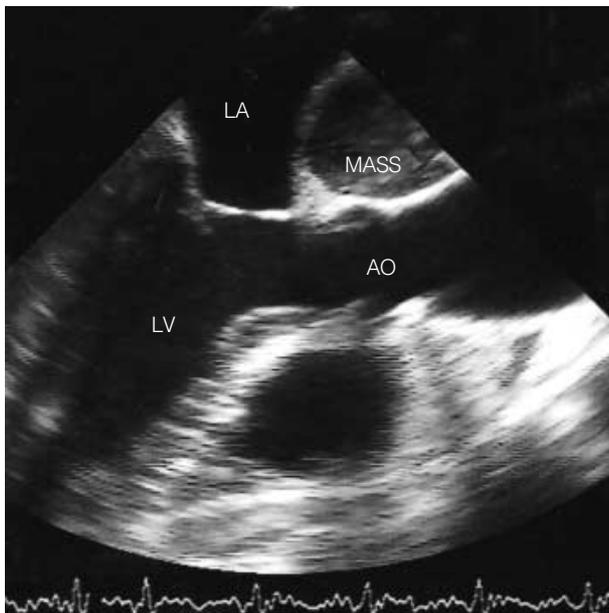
Transesophageal echocardiogram (128° view) shows a well-marginated interposed mass between the left atrium and aorta. LA, left atrium; AO, aorta; LV, left ventricle.
